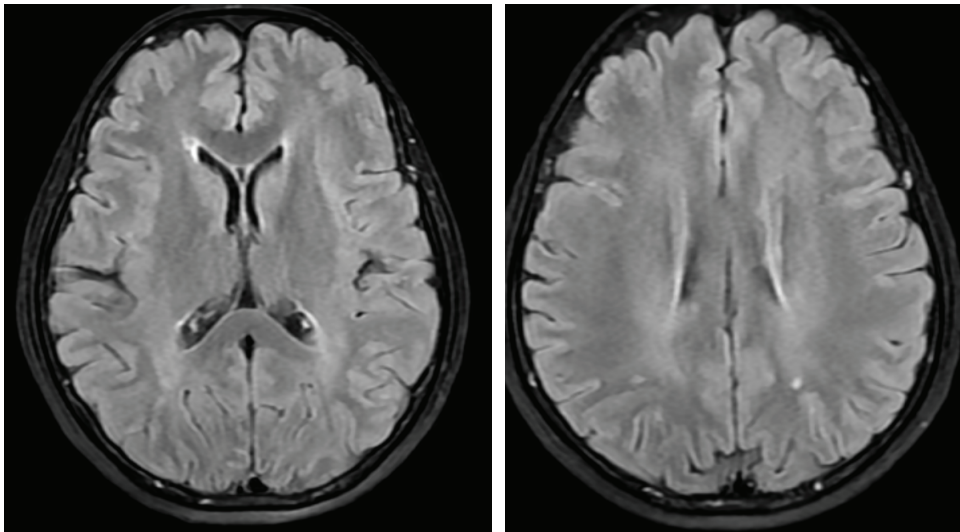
White Matter Lesions on Brain MRI (Lynx Ear Sign)
